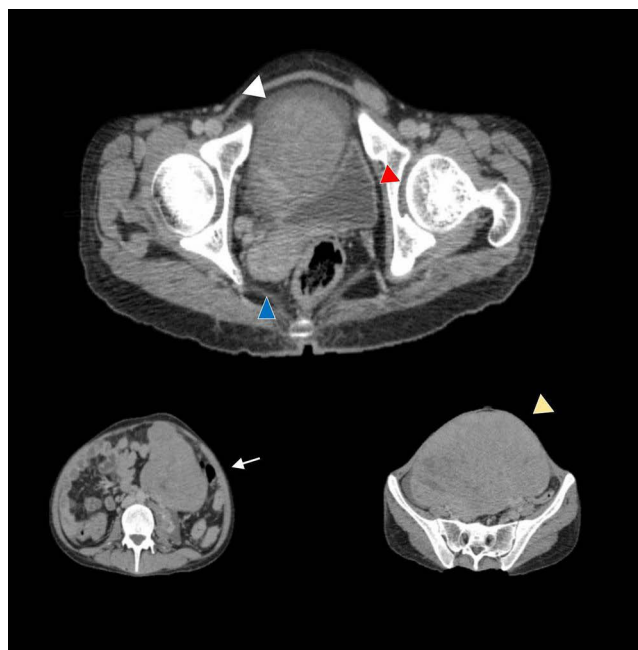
CT scan images depicting the uterus and a left adnexal mass. The white arrowhead indicates the left adnexal mass, the red arrowhead marks the urinary bladder, the blue arrowhead denotes the uterus, the yellow arrowhead highlights different levels of the mass, and the white arrow points to the mass adjacent to the right adnexa.
